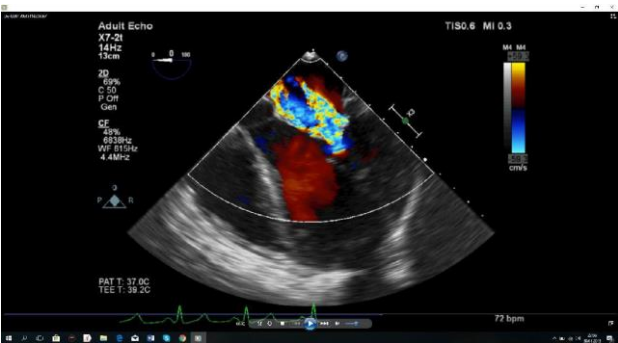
Middle esophageal four-chamber image showing advanced mitral insufficiency (colored Doppler imaging)
